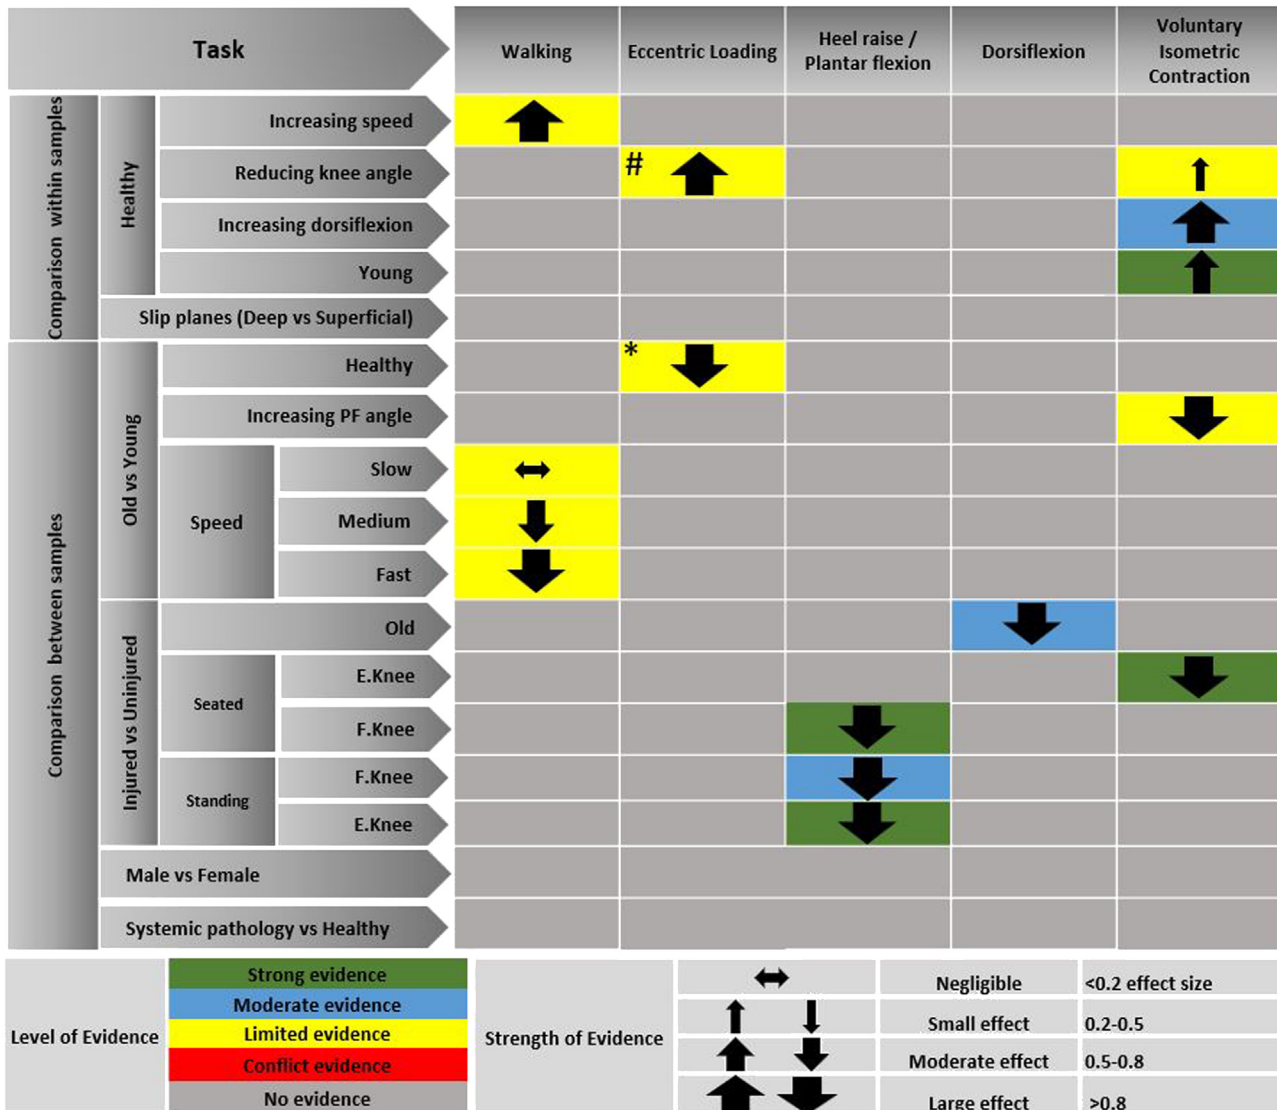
An evidence gap map of human free Achilles tendon deformation patterns measured using ultrasound. Arrow direction (upward = increase) represents the direction of deep tendon displacement compared with the superficial layer. Example interpretations: (between group) *During eccentric loading, there is limited evidence of large effect that the difference in deeper tendon displacement compared with superficial is less than that in younger participants. (within group) #During eccentric loading, there is limited evidence of large effect that reducing knee angle causes more deep tendon displacement compared to superficial. Degree of displacement of the deep Achilles tendon compared with the superficial layer.
